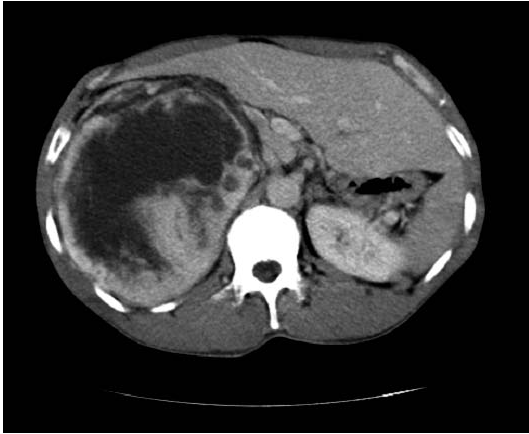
Contrast computed tomography scan demonstrating an enhanced, well-demarcated tumor of the left kidney with multinodular configuration. The tumor involved the renal cortex and perirenal adipose tissue.
